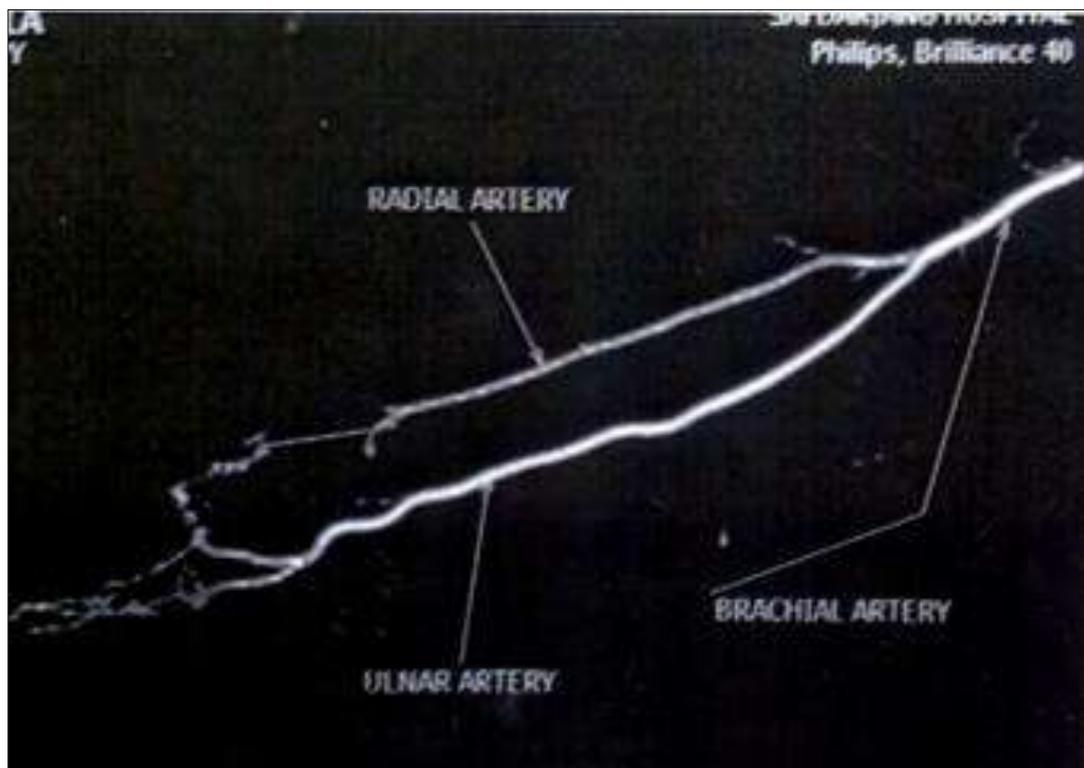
CT Angiogram showing narrowing of the distal part of radial artery
